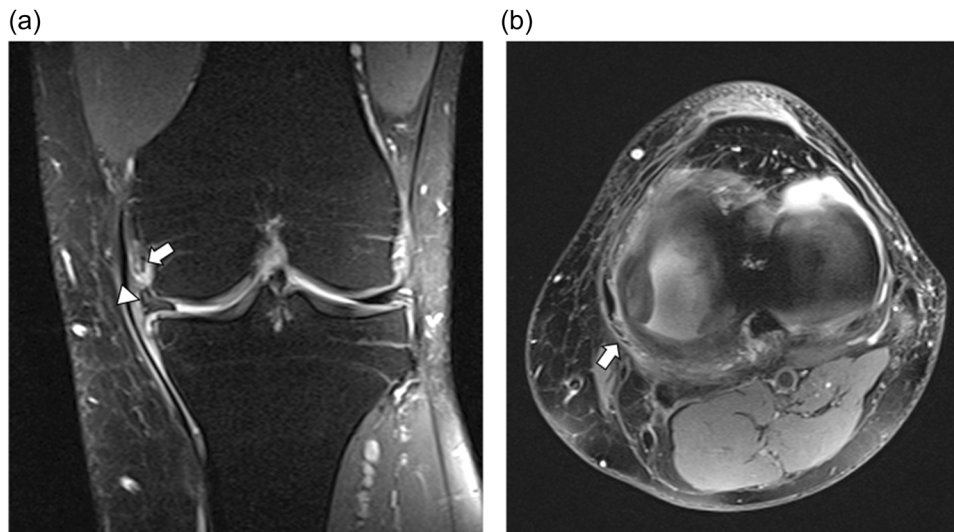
Coronal (a) and axial (b) proton-density-weighted fat-saturated magnetic resonance images of a 47-year-old male patient showing an associated RAMP type 2 lesion (white arrowhead in a) and anterolateral ligament complete lesion (white arrow in a and b).
